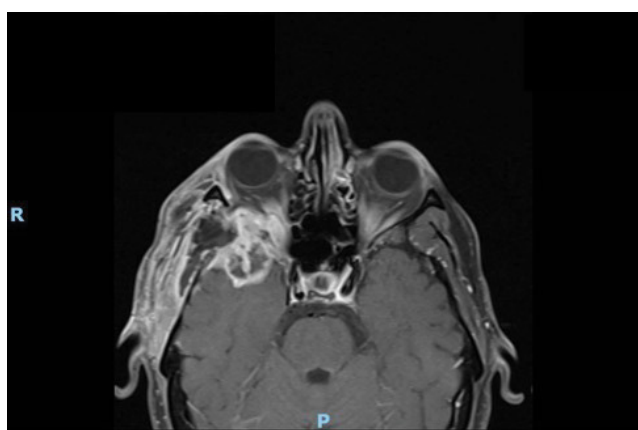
MRI T1 axial image, 3 months after surgery.
